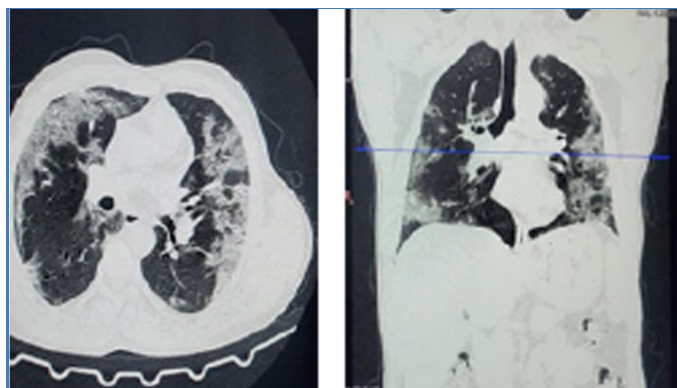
HRCT Chest showing multifocal patches of ground glass opacities
